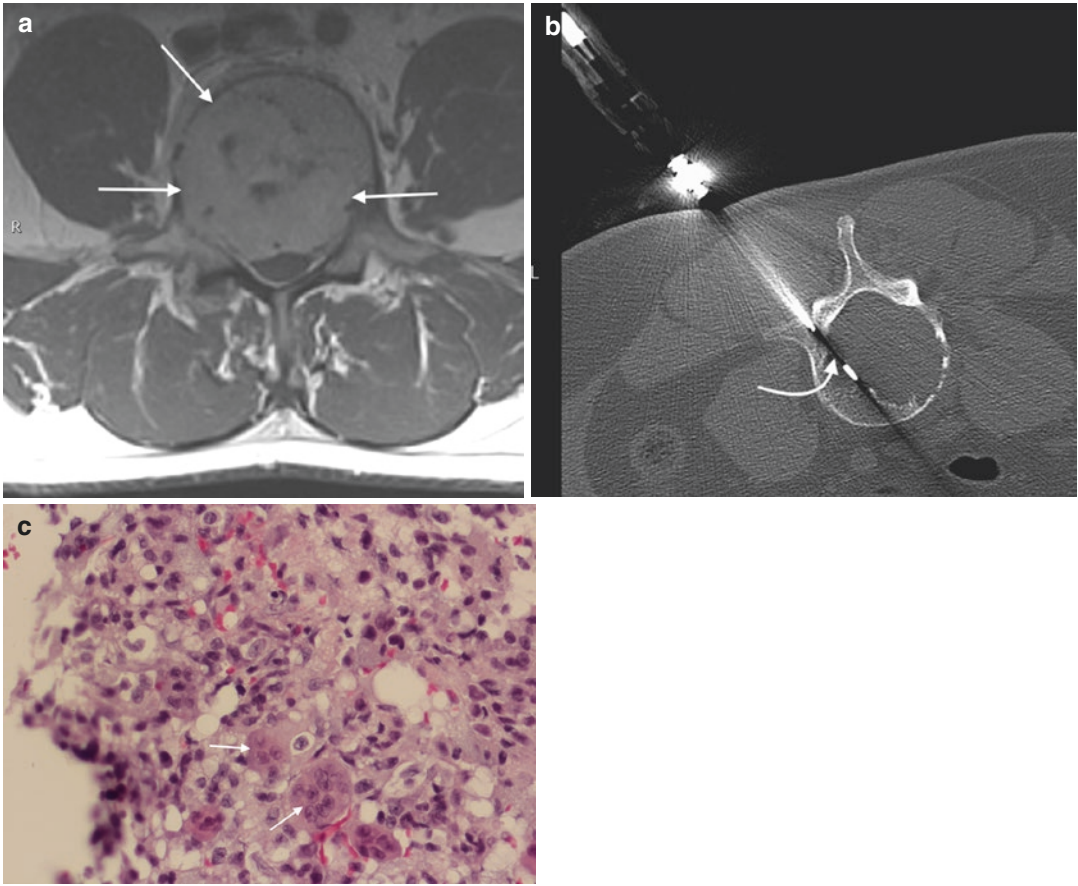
A 47-year-old male with low back pain (same patient as in Fig. 5, Chap. 6). Contrast-enhanced T1-weighted axial image (a) shows large enhancing mass (arrows) within the L4 vertebral body. Axial CT image (b) shows transpedicular coaxial placement of a soft tissue
